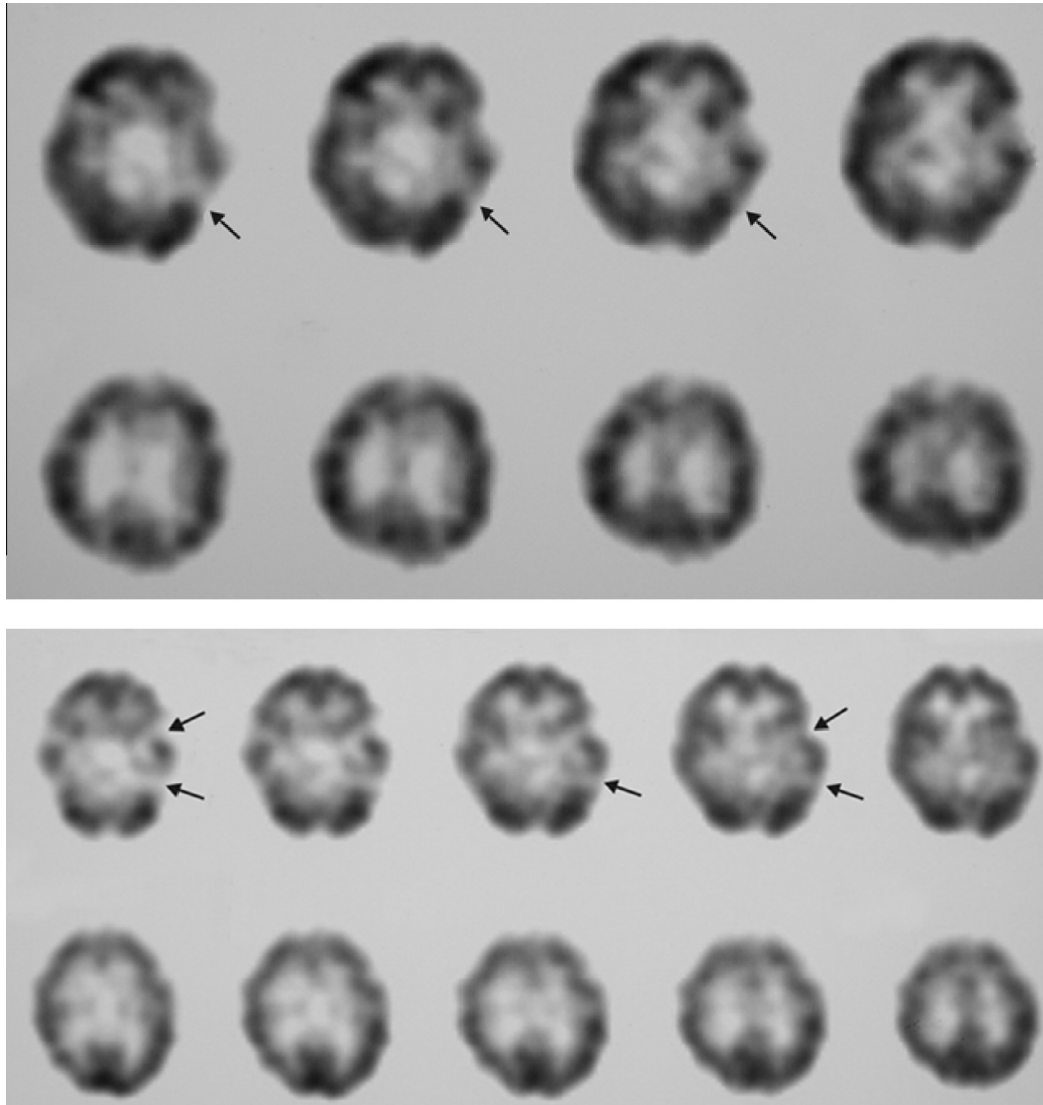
SPECT of patient 2 shows hypoperfusion in left parietotemporal (top), SPECT of patient 7 shows hypoperfusion in left temporal, posterior parietal, and basal ganglia (lower).
